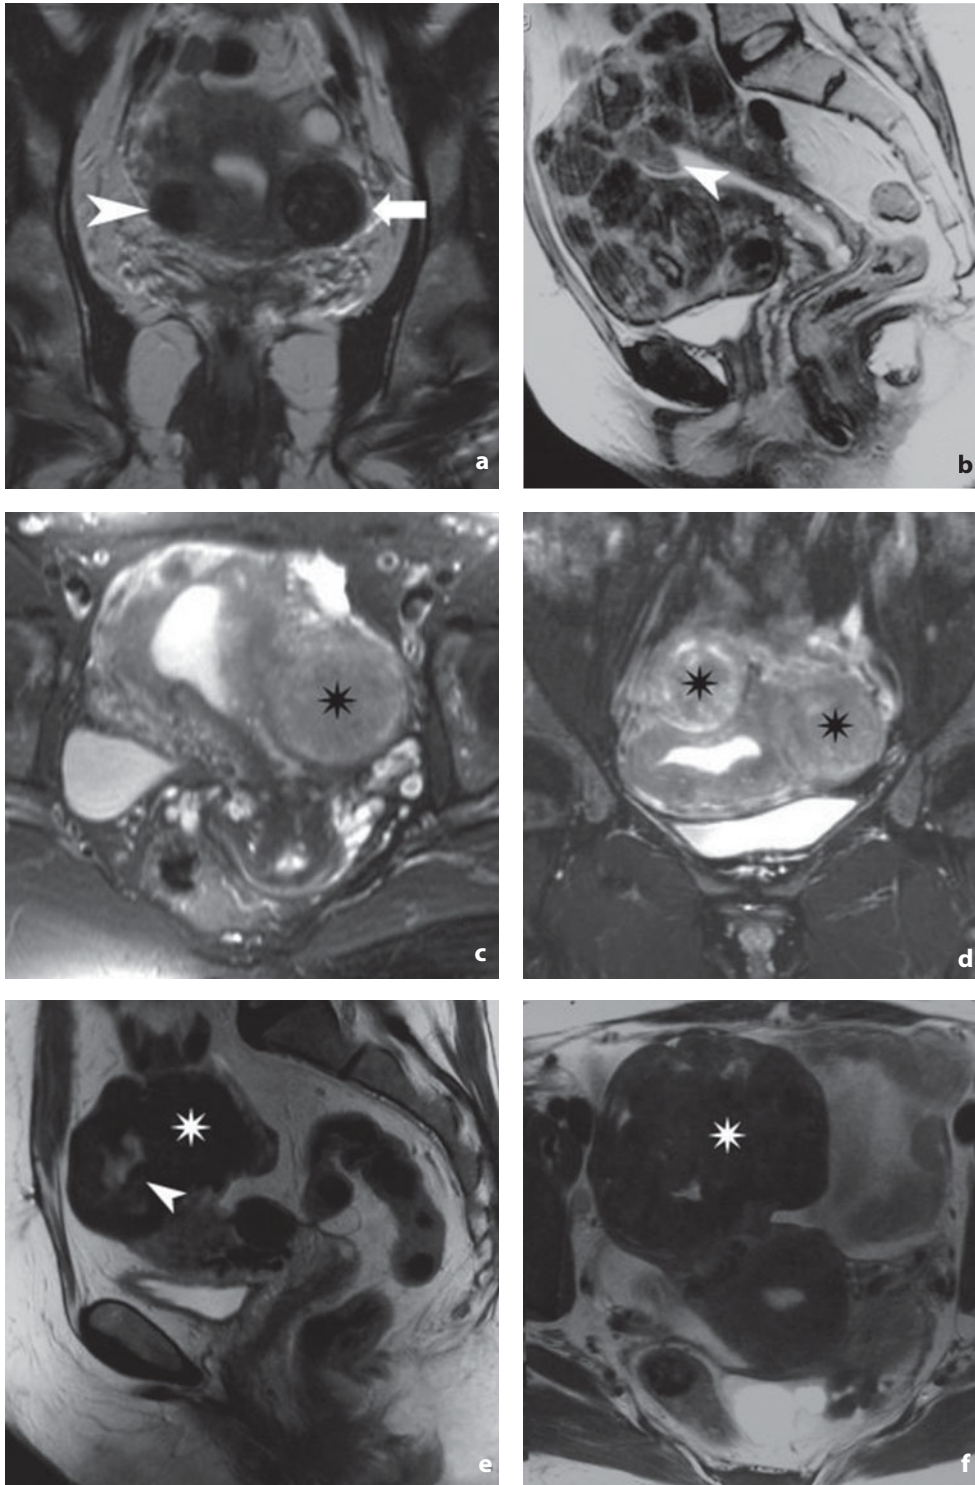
Magnetic resonance. Leiomyomas. a Coronal T2-weighted image. Intramural (*arrowhead*) and subserous (*arrow*) leiomyoma. b Sagittal T2-weighted image. Multiple intramural leiomyomas cause a change in morphology and volume of the uterus. A small submucosal leiomyoma (*arrowhead*) can be seen protruding into the endometrial canal. c,d Axial (c) and coronal (d) T2-weighted fat saturation images. The *asterisks* indicate two subserous exophytic leiomyomas. e,f Sagittal (e) and coronal (f) T2-weighted images. Large subserous leiomyoma (*asterisk*) with evidence of a small area of cystic degeneration (*arrowhead*)
